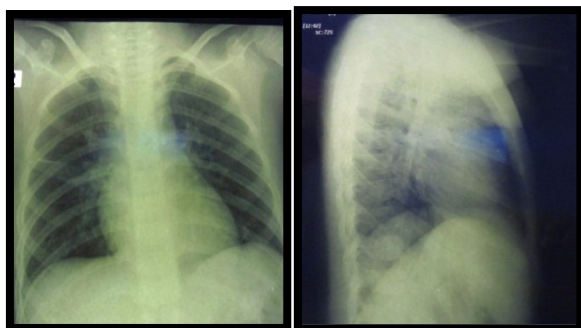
Thorax x-ray examination AP- lateral position post operation
